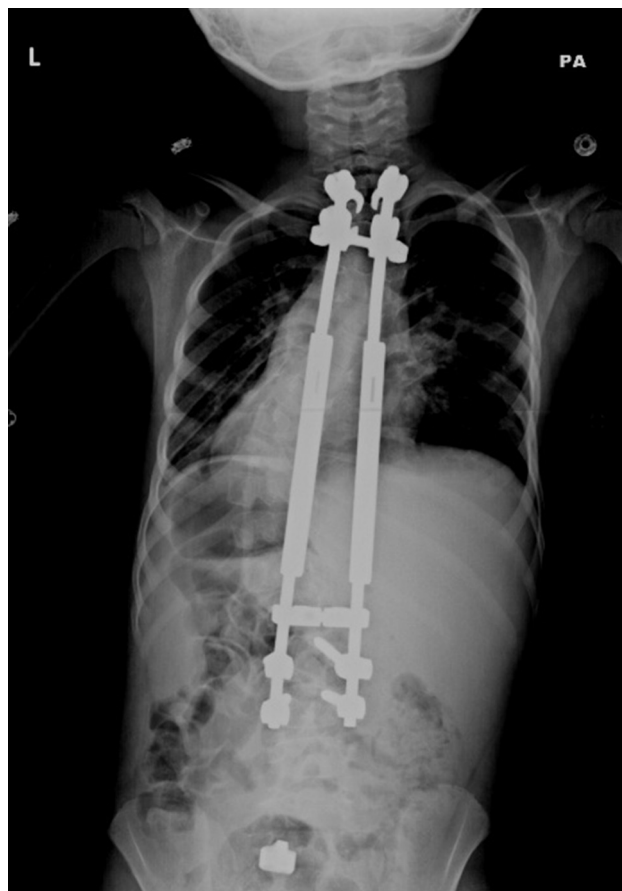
Posteroanterior (PA) radiograph of a patient with proximal spine anchors.
